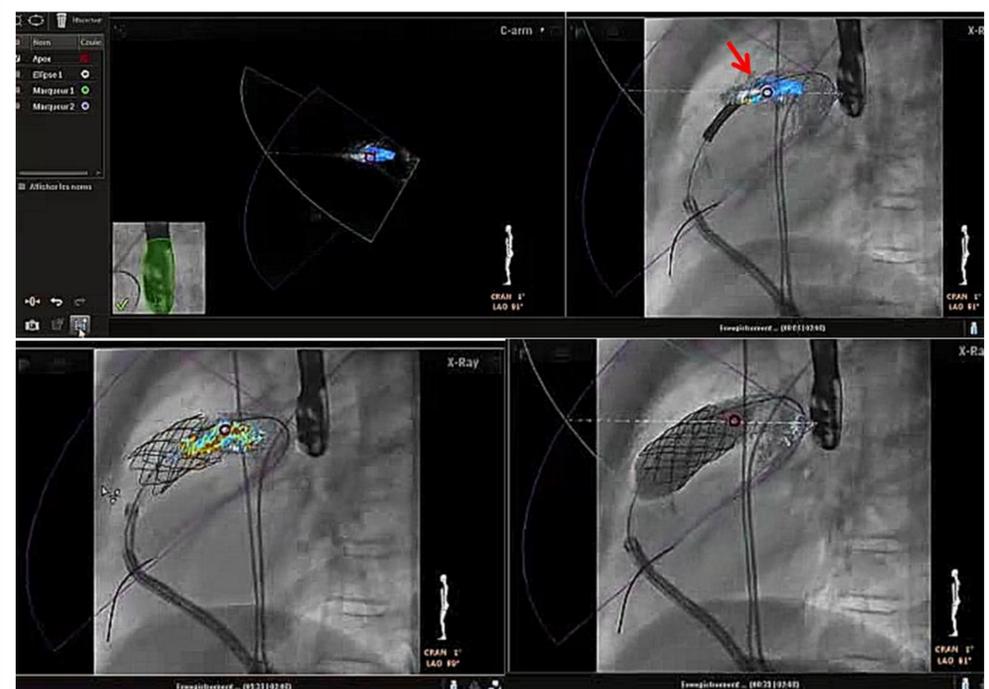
Image fusion during pulmonary outflow tract reevaluation procedure using Melody valve. Marker was placed at the leading zone on biplane TEE images (upper right screen) and automatically projected at the fluoroscopic screen (red arrow), Fusion of 2D color echocardiographic image enables to evaluated the absence of residual regurgitation (lower right screen).
